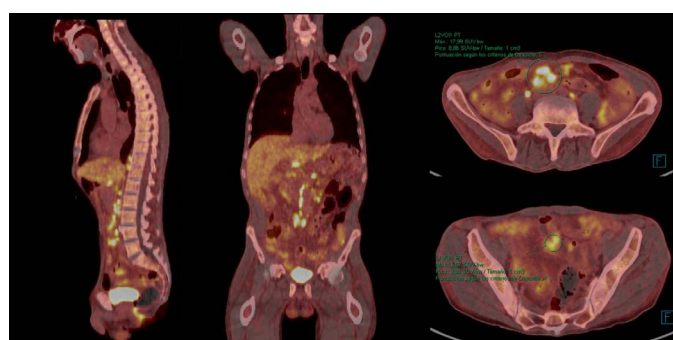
PET-CT scan for re-evaluation of previously studied adenopathies with the finding of hypermetabolic supra and infra diaphragmatic adenopathies suggestive of a neoplastic process.
